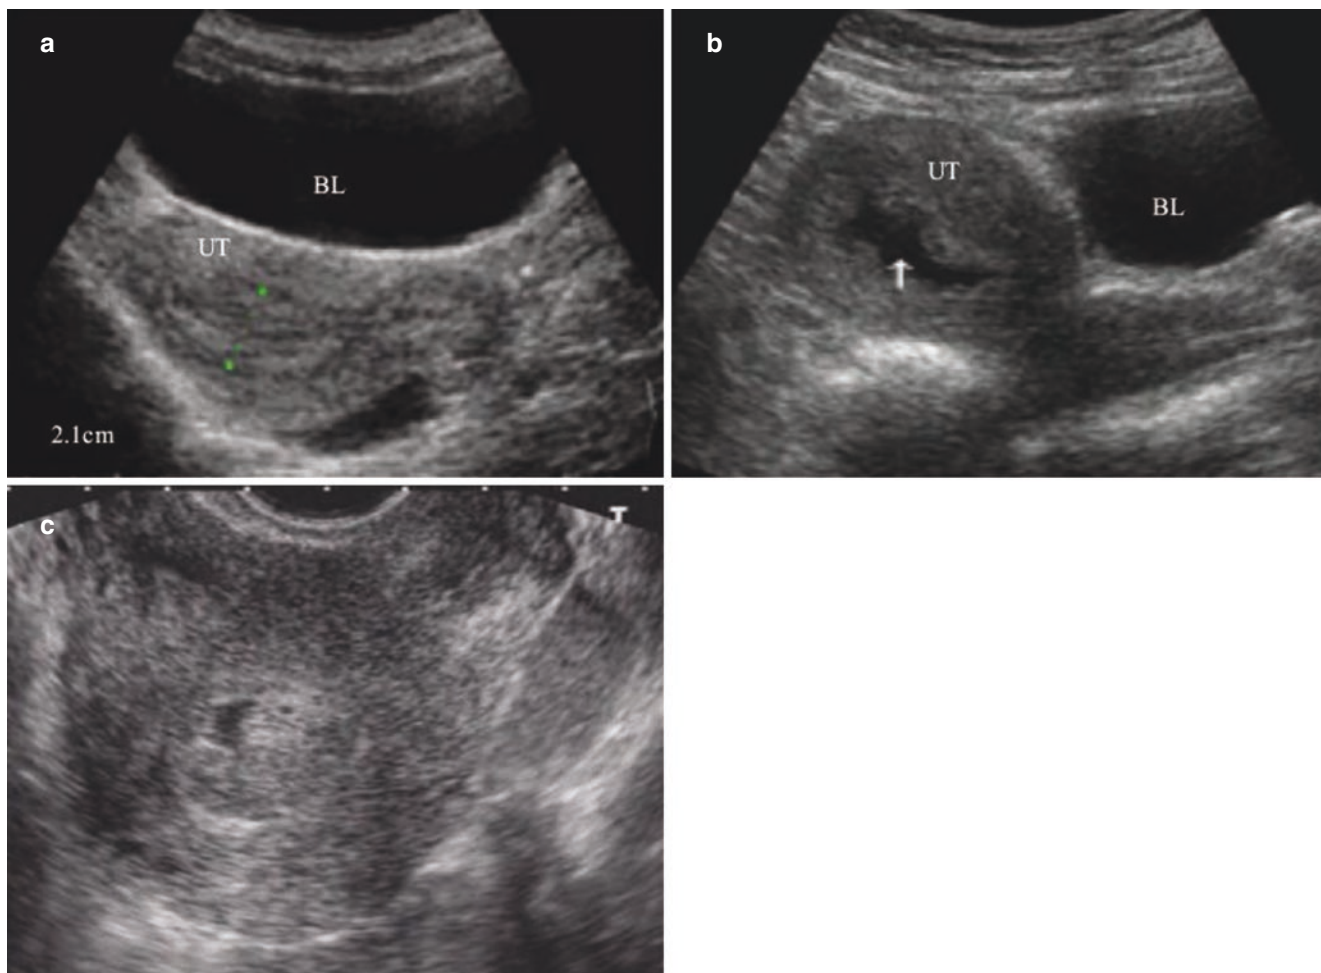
Ectopic pregnancy. (a-c). The sonogram shows the enlarged uterus, thickened endometrium, uterine cavity hematocoele, and intrauterine pseudogestational sac
